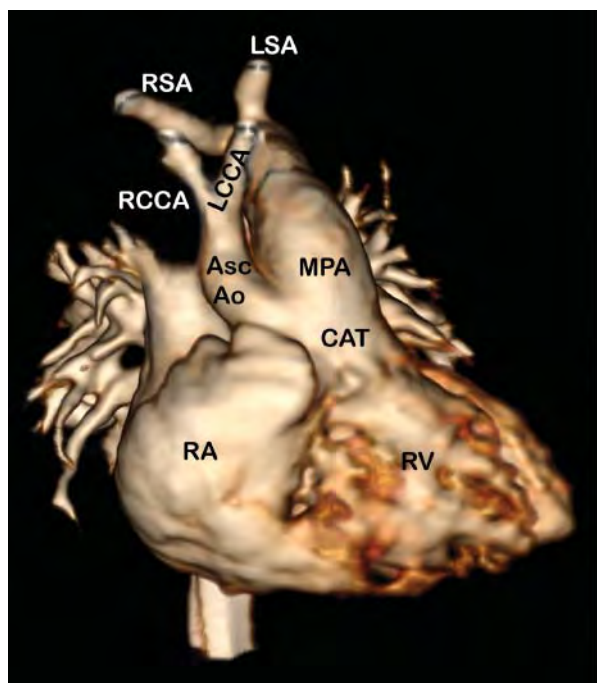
Computed tomographic 3D reconstruction of common arterial trunk (CAT) with type B interrupted aortic arch and aberrant right subclavian artery (RSA).
